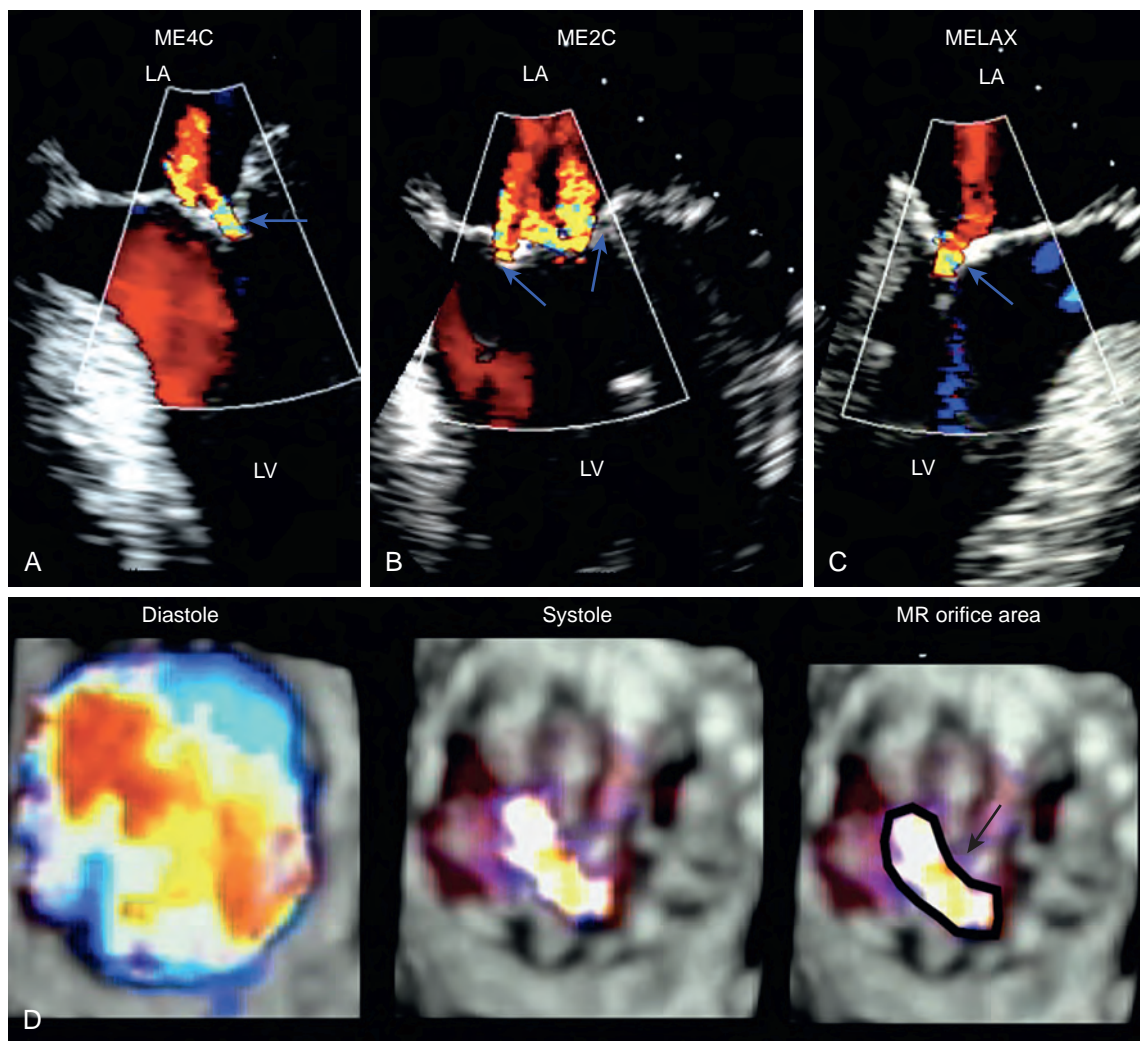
Three-dimensional (3D) image of the regurgitant orifice. (A–C) Two-dimensional appearances of the same mitral regurgitant jet from three different midesophageal (ME) echocardiographic windows: four-chamber (4C), two-chamber (2C), and long-axis (LAX), respectively. Vena contracta measurements from the ME4C and MELAX views are more accurate correlates of mitral regurgitation (MR) severity as they measure perpendicular to the MR jet, while the ME2C window views parallel to the MR jet. (D) This is confirmed using 3D imaging of the regurgitant jet during diastole (left) and systole (middle) from the left ventricular (LV) perspective. The shape of the regurgitant orifice, during systole on the right, is elliptical. The implications are that the effective regurgitant orifice is not circular and the flow convergence (proximal isovelocity surface area [PISA]) is not hemispherical as the principle behind the equation assumes it to be, creating errors in the PISA method. Three-dimensional imaging, when feasible, allows a direct measure of the regurgitant orifice area shown in black (right).
